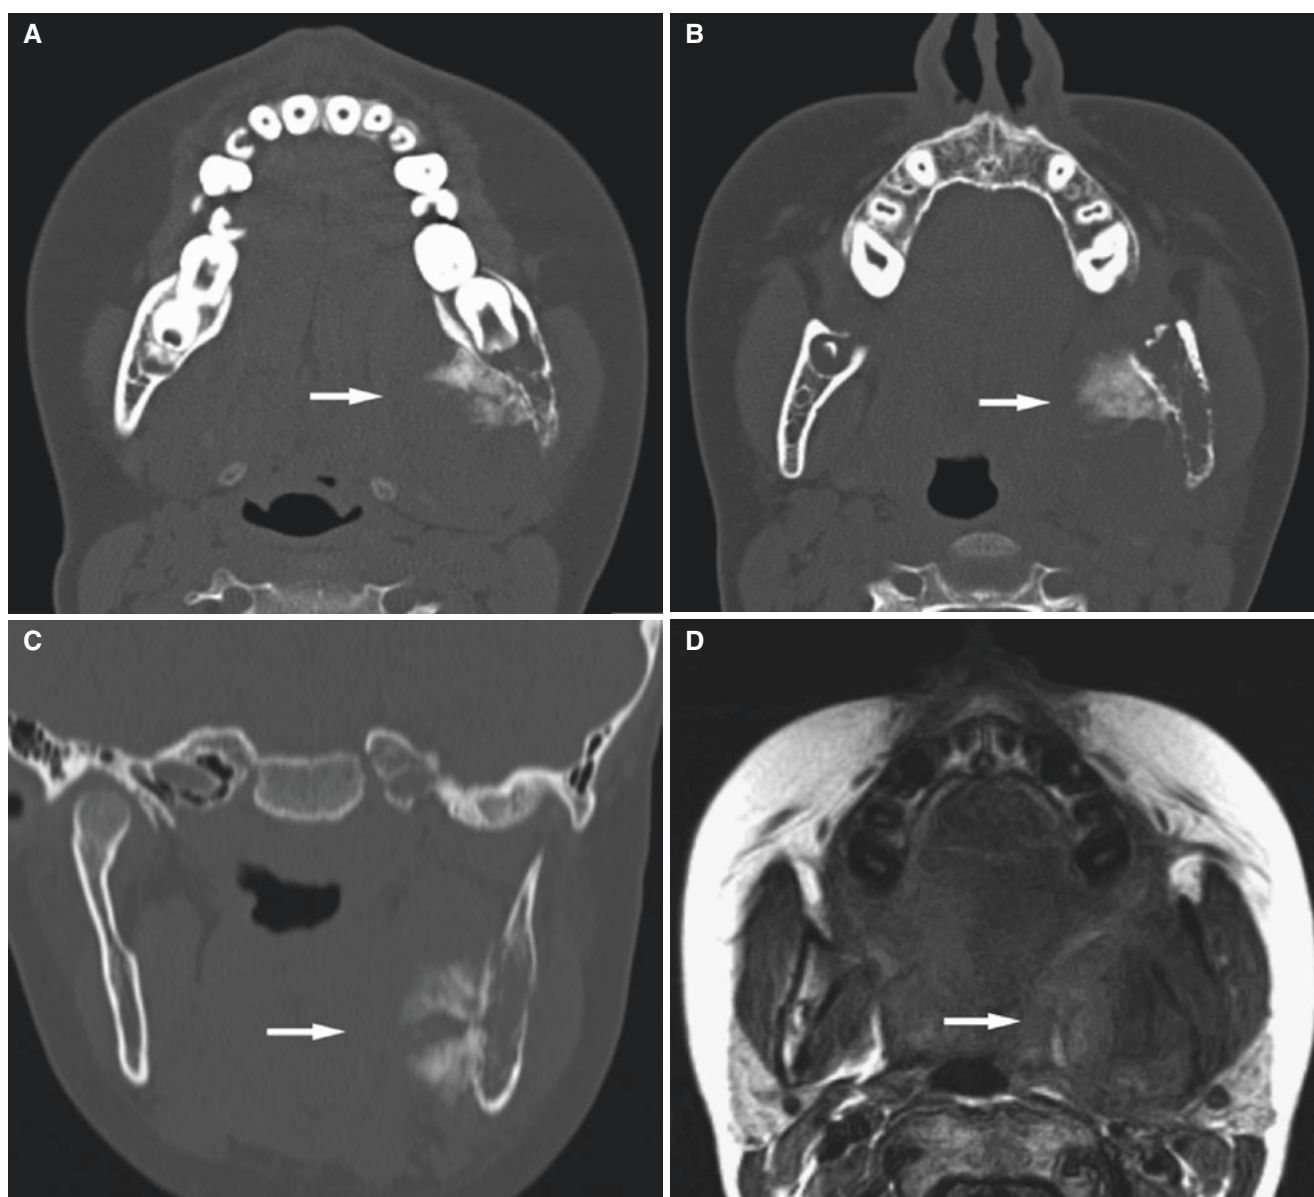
Osteosarcoma, mandible; 10-year-old female with painful mass in the mandible and inability to open her mouth and 3-year history of femur osteosarcoma. (A) Axial CT image shows radiating bone production on lingual aspect of the mandible (*arrow*). (B) Axial CT image shows bone production and destruction of bone marrow and cortex (*arrow*). (C) Coronal CT image shows sunburst appearance (*arrow*). (D) Axial T1-weighted pre-Gd MRI shows intermediate-low-signal
